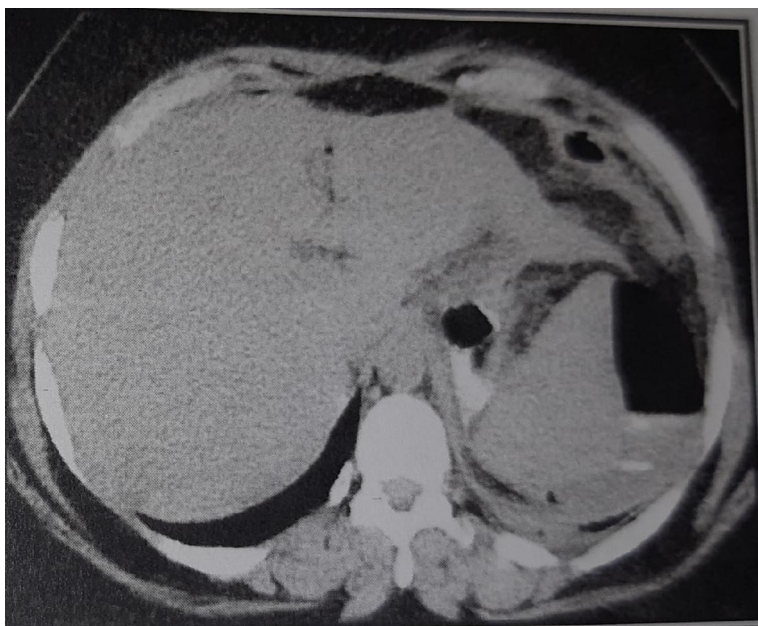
CT showing leakage.
